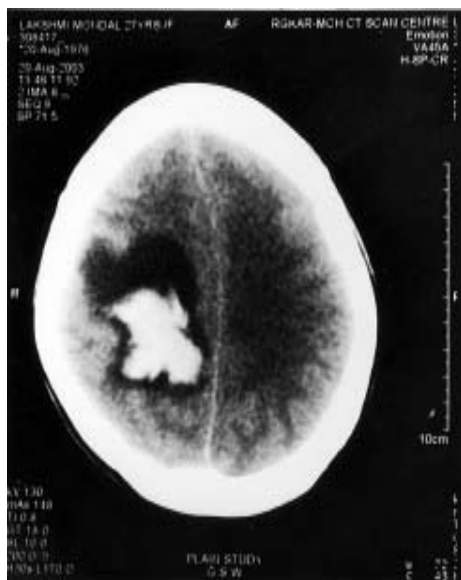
CT scan showing intracerebral hemorrhage with mass effect.
